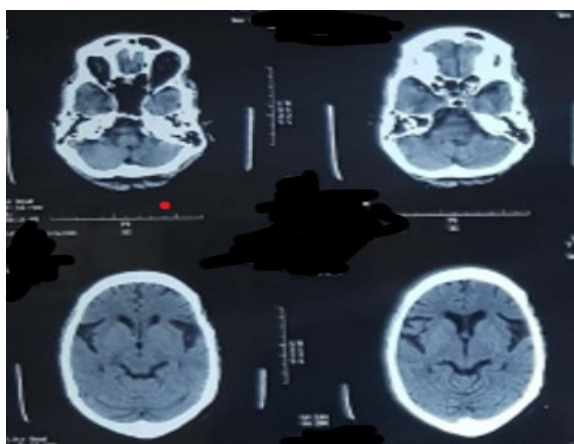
CT Brain plan axial view
